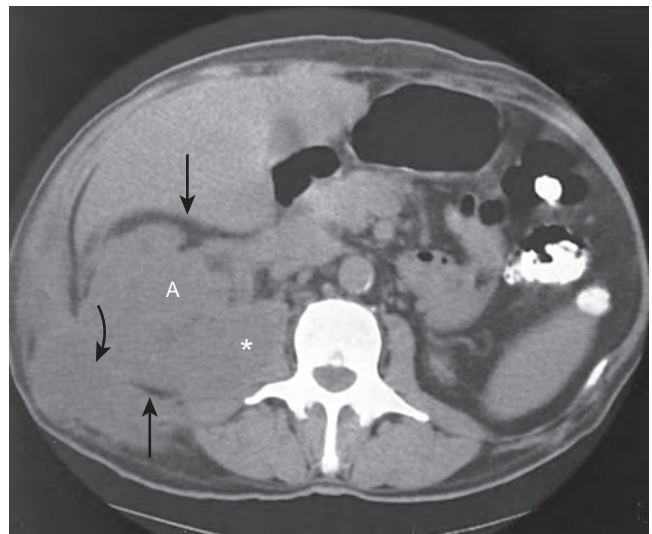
Nonenhanced computed tomography scan through the lower pole of the right kidney (previous left nephrectomy) shows extensive perinephric abscess. Extensive abscess (A) distorts and enlarges the renal contour, infiltrates perinephric fat (straight arrows), and also extends into the psoas muscle (asterisk) and the soft tissues of the flank (curved arrow). Also note that normal renal collecting system fat has been obliterated by the process.
